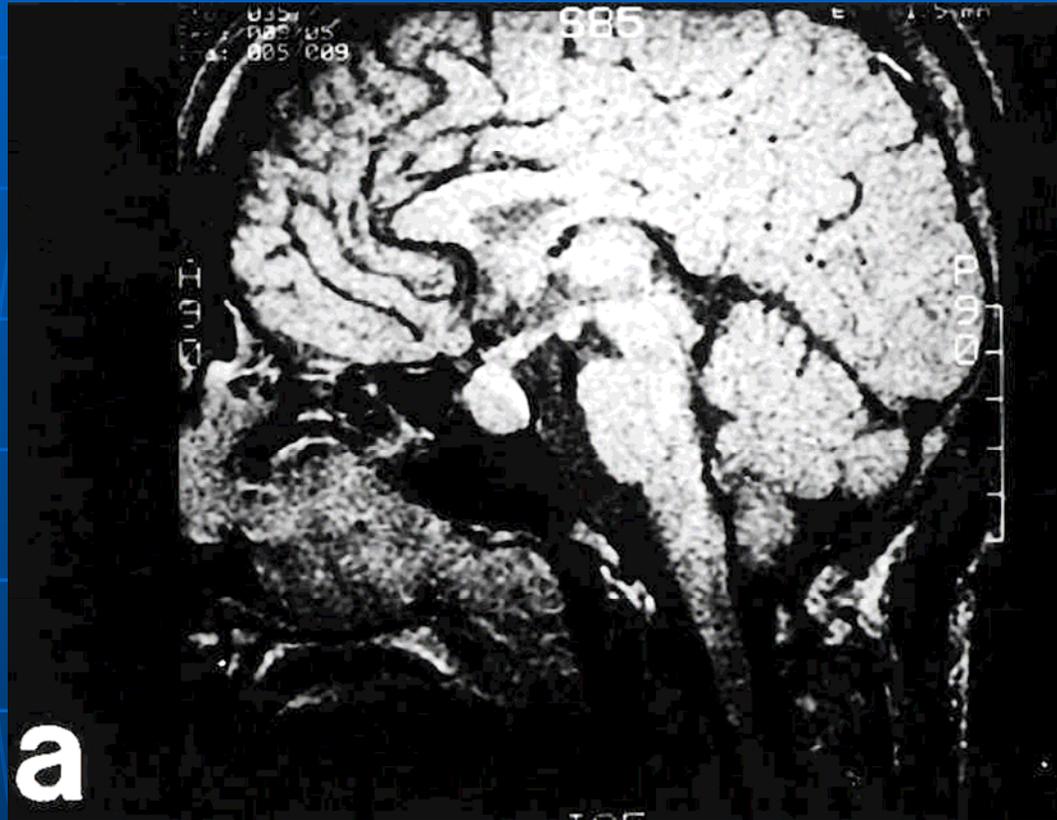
Brain MRI imaging
